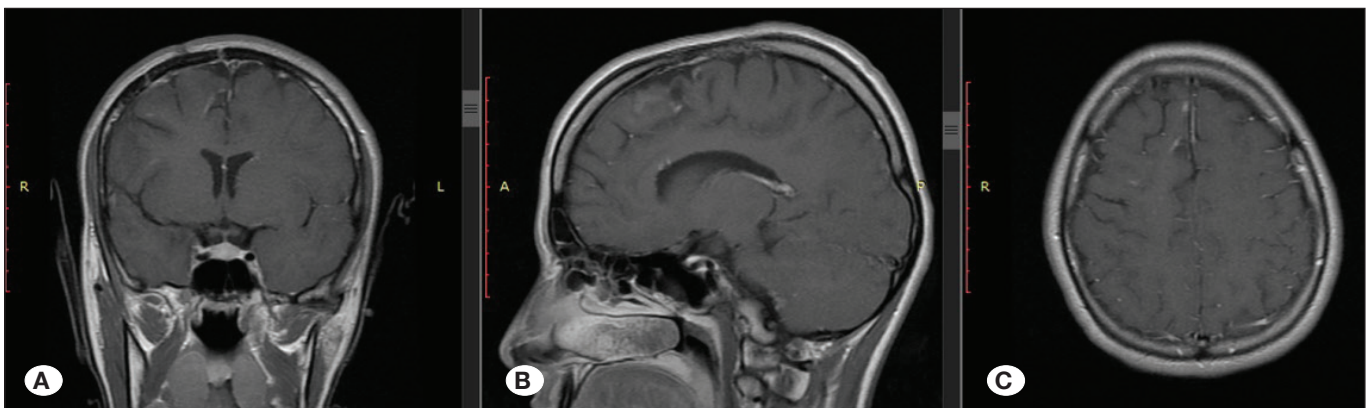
MRI features were totally regressed after treatment with oral albendazole for 3 months. Coronal (A), sagittal (B) and axial (C) MRI scans after a year in follow-up.
